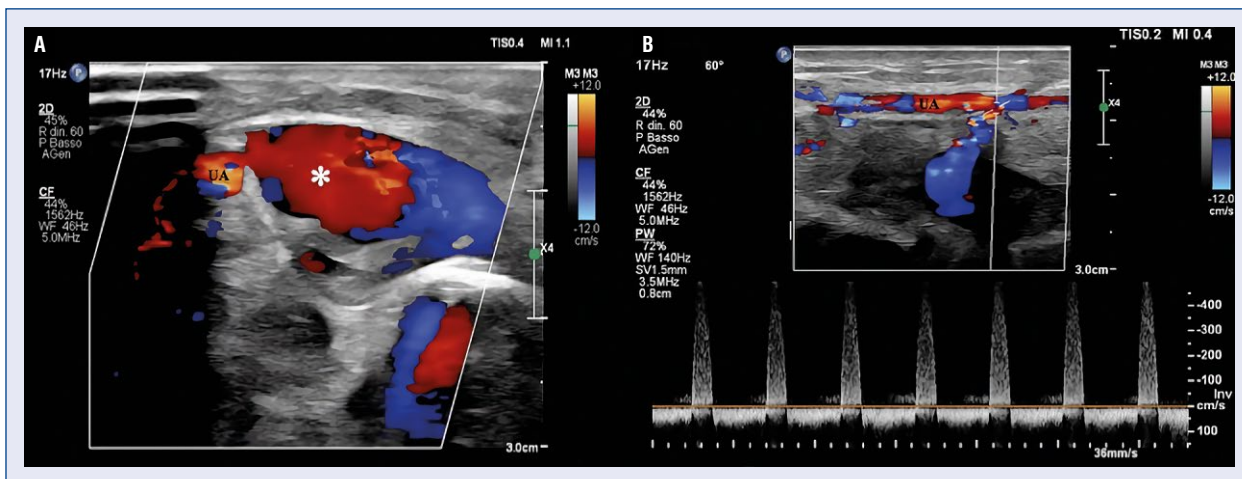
A. Color Doppler ultrasonography showing a 15 × 35 mm pseudoaneurysm (asterisk) of the ulnar artery with a kind of ‘yin and yang’ pattern, indicating bidirectional blood flow inside the cavity; B. Spectral Doppler revealing systolic and diastolic turbulent blood flow with traditional “to-and-fro” waveform.
